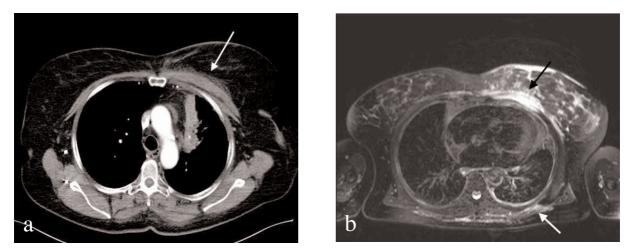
CT scan (a) and MR scan (b) of the thorax showing marked thickening of the pectoral and dorsal paraspinal muscles.
